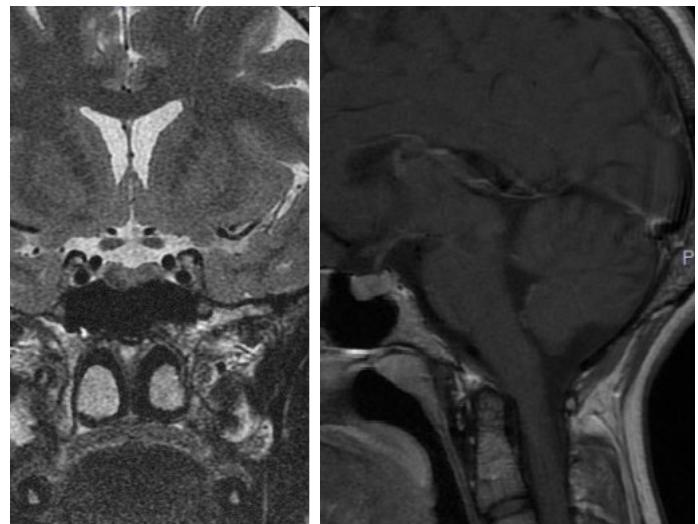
MRI showed a 7×5 mm microadenoma located in the adenohypophysis.
